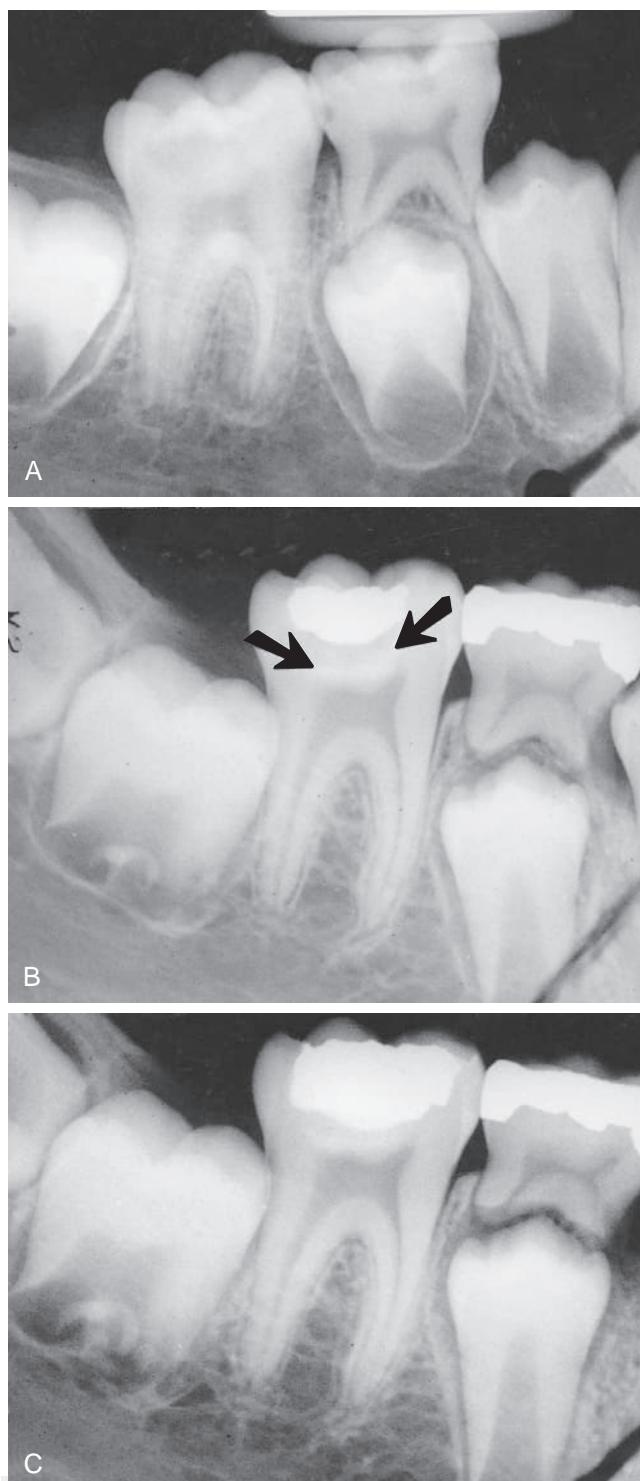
(A) Radiograph of the first permanent molar revealed a deep caries lesion. Gross caries was removed, and calcium hydroxide was placed over the remaining caries. The tooth was restored with amalgam and was not re-entered for complete caries removal for 3 months. (B) Sclerotic dentin can be seen beneath the remaining caries and the covering of calcium hydroxide (arrows). (C) The tooth was re-entered, and the remaining caries was removed. A sound dentin barrier was observed at the base of the cavity. A new amalgam restoration was placed after complete caries removal.
